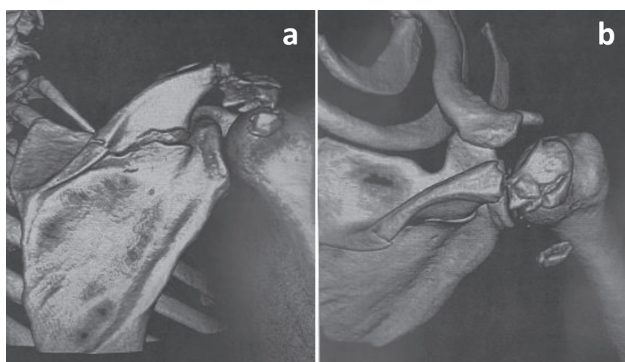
3D reconstruction of the preoperative CT scan. a) Posterior view; b) upper view
